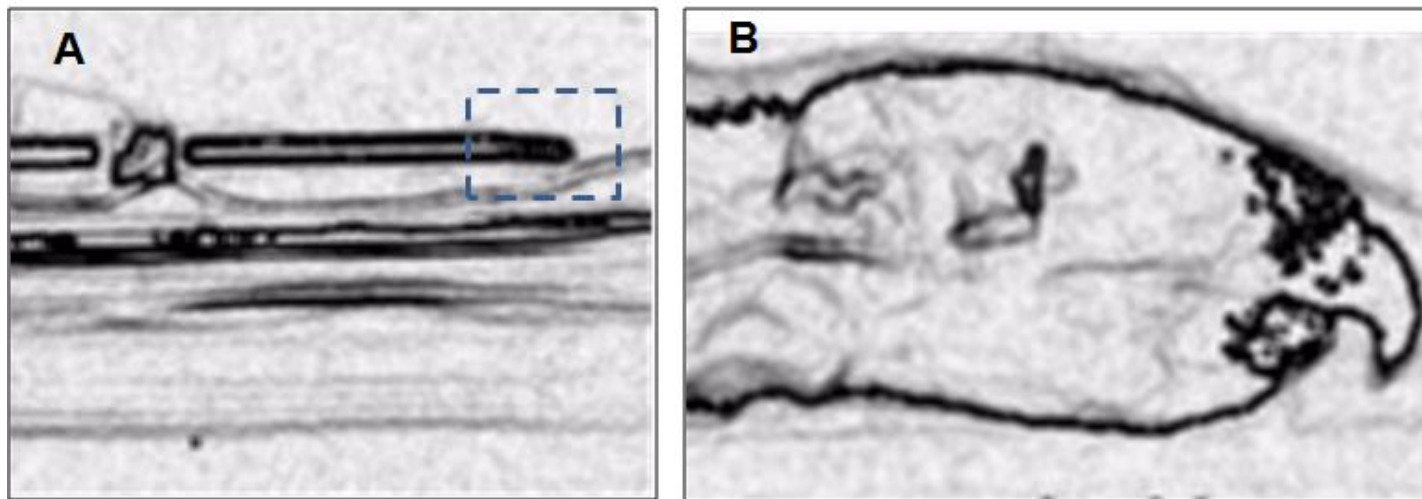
Two dimensional images obtained during three dimensional rotational scanning. The balloon model is shown in frame A while frame B shows the outline of the ventricular system when iohexol was infused through the shunt at 3  $\mu\text{L}/\text{min}$ . Darkened regions correspond to attenuation of the x-ray or iohexol-mixed region. The low resolution did not allow for accurate three dimensional reconstructions.
